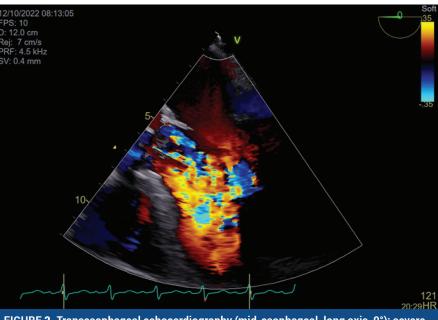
Transesophageal echocardiography (mid-esophageal, long axis, 0°): severe aortic regurgitation jet across the whole left ventricle.
